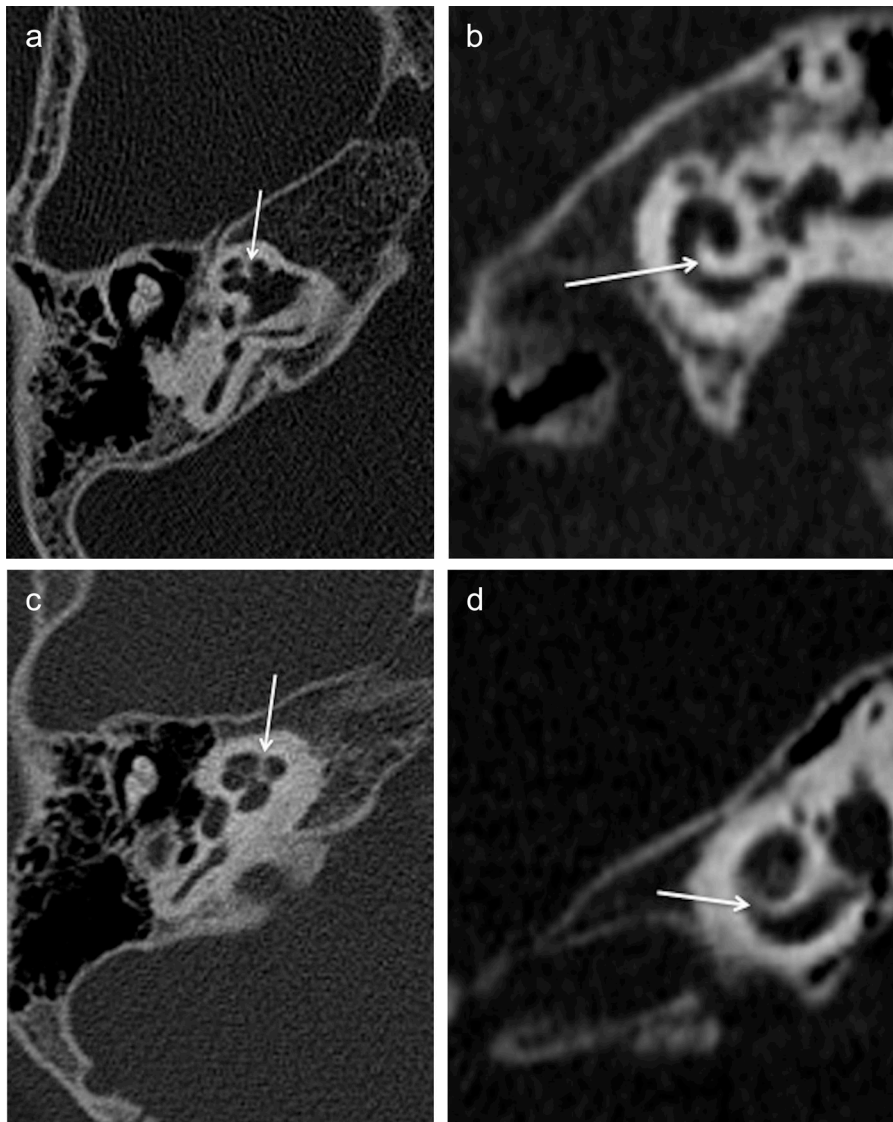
a-d. CT imaging findings of a 2-year-old male patient with XLD. Absent cribriform plate and modiolus of the cochlea with thickened interscalar septa (a, b, arrows). CT images of a 2-year-old patient with normal inner ear findings for comparison (c, d).
